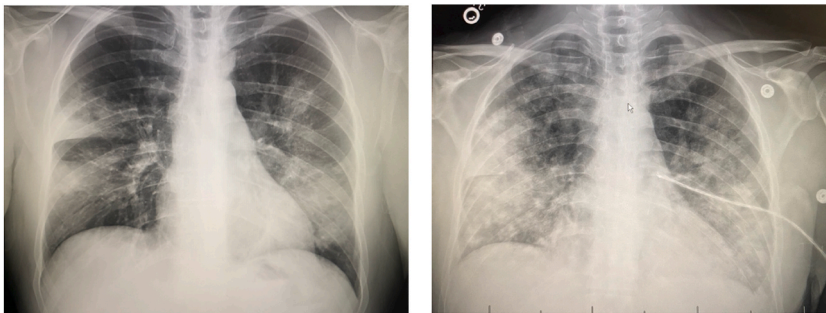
Initial chest radiograph demonstrating the presence of mixed interstitial and airspace opacities in the left mid-lung and right upper lobe (left panel). Subsequent chest radiograph prior to intubation demonstrating interval worsening (right panel).
